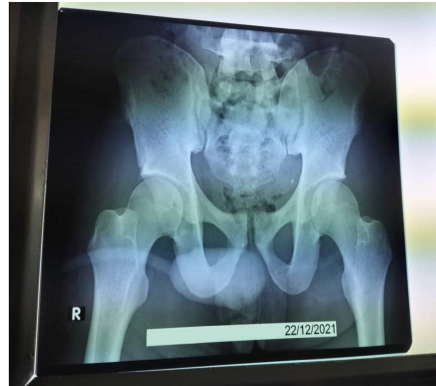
Normal X-ray of the bony pelvis.
